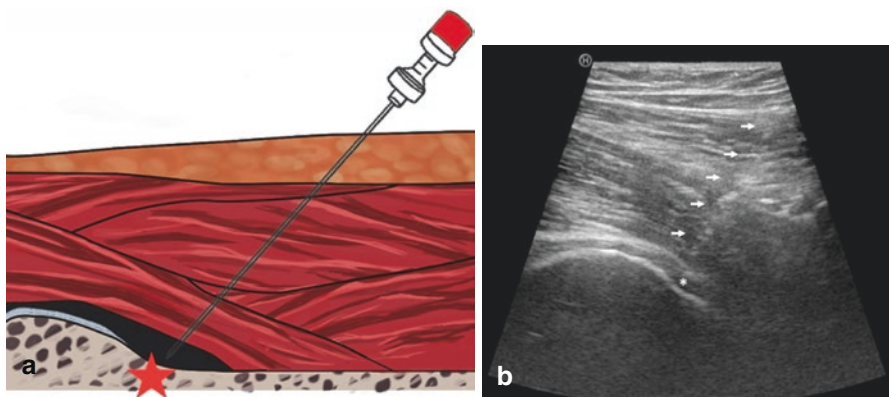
US hip injection technique, anterior approach. (a) The needle is inserted approximately 2 cm from the distal part of the probe with an angle of about 45° to the horizontal skin plane having as a target the head-neck junction (red star). (b) The needle insertion can be traced from the moment it enters the ultrasound beam, approximately 1 cm below the skin, through the fat tissue, rectus femoris and iliopsoas muscle and capsule, up to the bone (white arrows) to the head-neck junction (asterisk)
